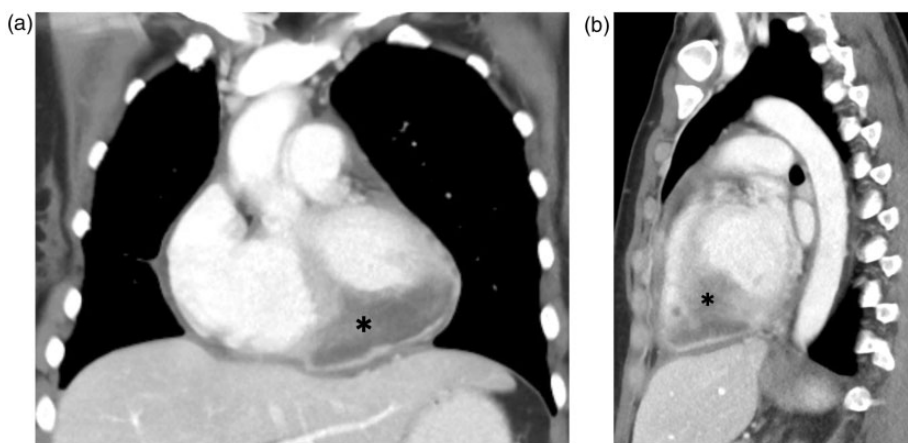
Coronal (a) and sagittal (b) reconstructions of contrast-enhanced CT scan. Cardiac mass involves the inferior and septal part of the biventricular myocardium (black asterisks).
